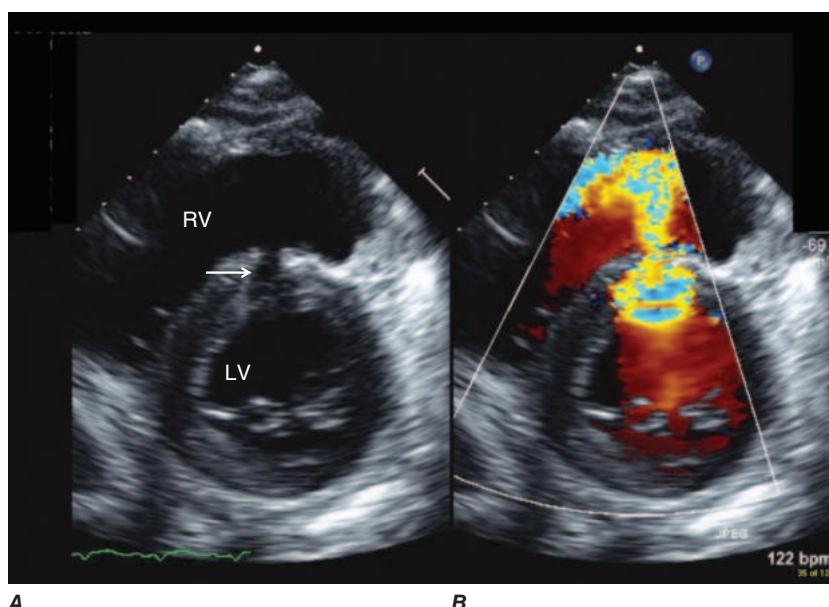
Transthoracic echocardiogram demonstrating a traumatic ventricular septal defect. The patient underwent emergent repair of the right ventricle following a self-inflicted stab wound to the chest. Subsequent two-dimensional imaging (A) revealed a laceration of the interventricular septum (arrow) with color flow Doppler (B) demonstrating prominent left-to-right shunting across the defect. LV, left ventricle; RV, right ventricle.
